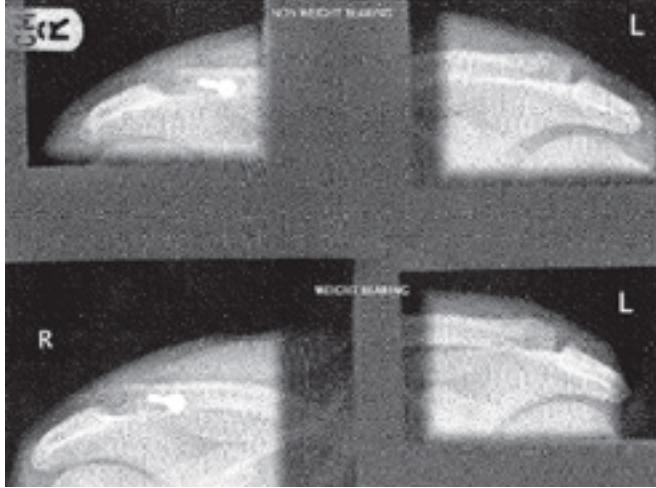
Post-operative x-rays of a Surgilig™ graft used on the right side [note the screw in the clavicle] and the normal left side for comparison. This patient even had inadvertent stress weight-bearing views.
